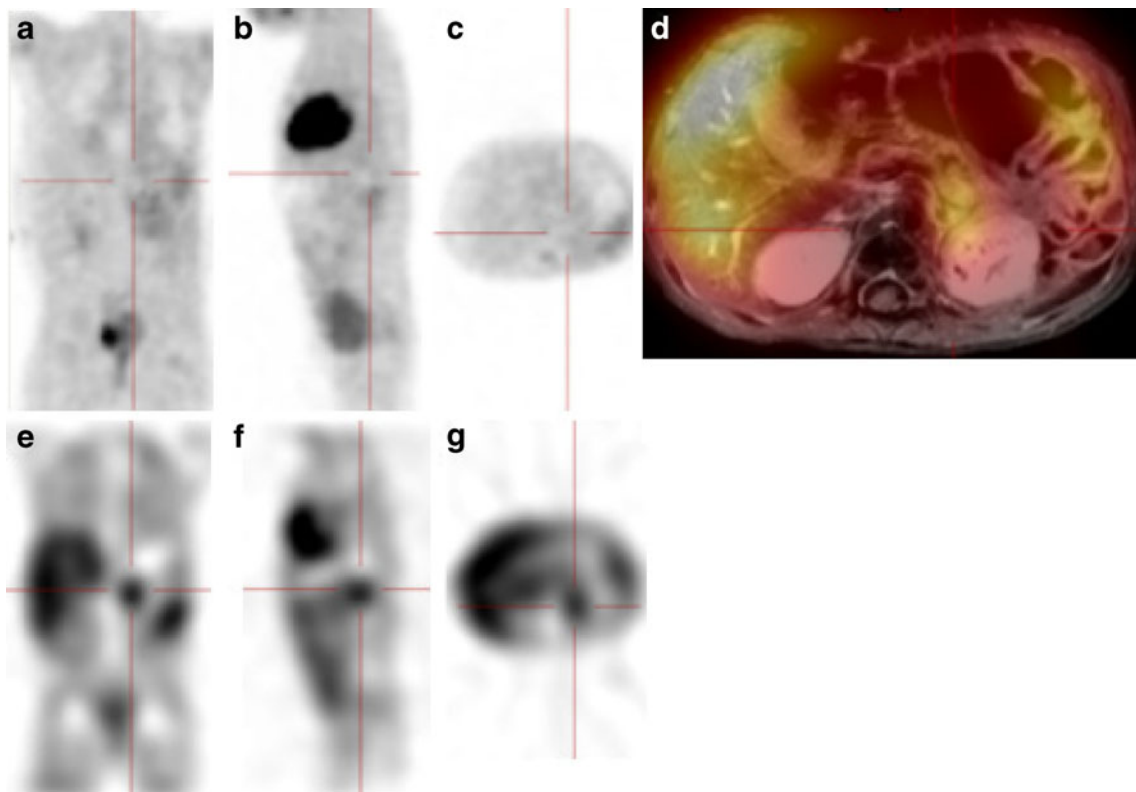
A 2-year-old girl with a left-sided persistent neuroblastoma after surgery and chemotherapy and a false-negative finding on ^{18}F -FDG PET. In the ^{18}F -FDG PET images no suspicious lesion is seen in the region of the left adrenal gland (a–c). On the MRI image it is not
